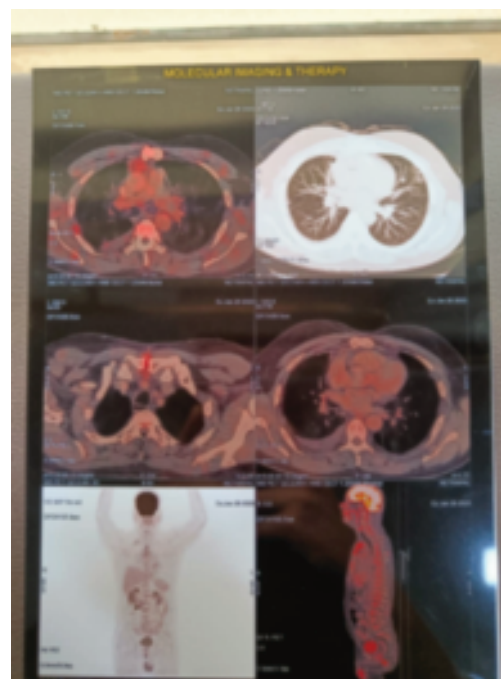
Post-procedural Positron Emission Tomography-Computed Tomography (PET-CT).
